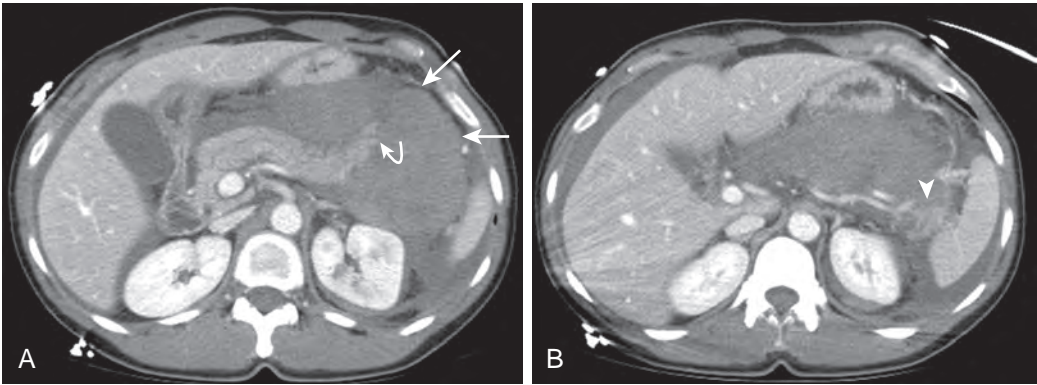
Pancreatic transection with retroperitoneal and intraperitoneal hemorrhage. A 42-year-old woman after a bicycle accident in which she suddenly braked and fell over the handlebars onto the pavement. A. Contrast-enhanced CT reveals a large amount of retroperitoneal and intraperitoneal hemorrhage (straight arrows). The pancreatic tail is deviated anteriorly by the hemorrhage (curved arrow). B. A portion of the transected pancreatic tail is seen in its expected location in the left upper quadrant (arrowhead). The diagnosis of pancreatic transection was confirmed at exploratory laparotomy, at which distal pancreatectomy and splenectomy were performed.
